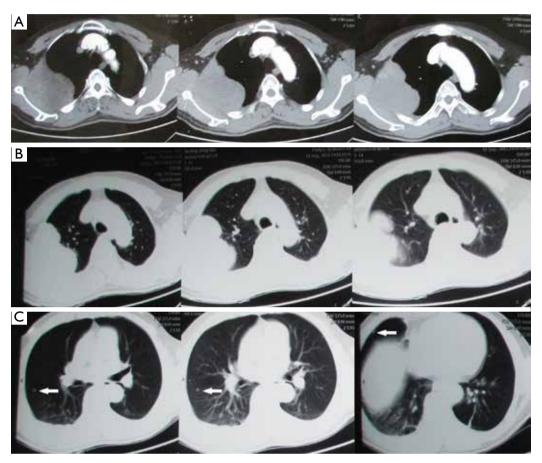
CT scan. Contrast-enhanced computed tomography (CT) showed that there was a large, nearly ovoid mass with dense soft tissue on the right side of the chest wall (A and B); some nodules were found and indicated using arrows in the right lung (C).
